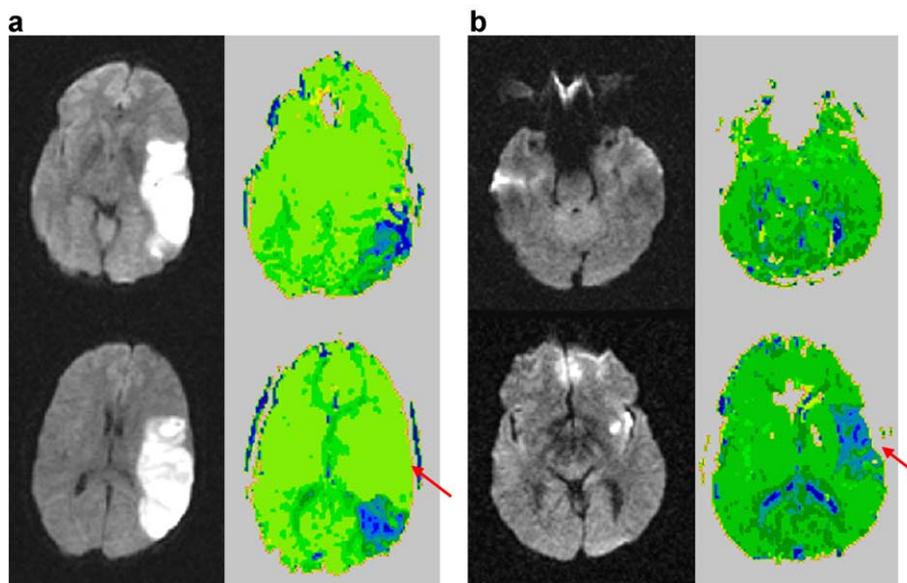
DWI and PWI scans of two patients with impaired written word comprehension and lexical decision with hypoperfusion or infarct of left posterior superior temporal lobe (BA 22). The purple arrows point to BA 22.
